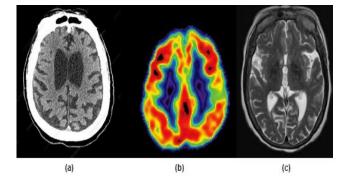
Samples of (a) CT, (b) PET, and (c) MRI scan of AD.
